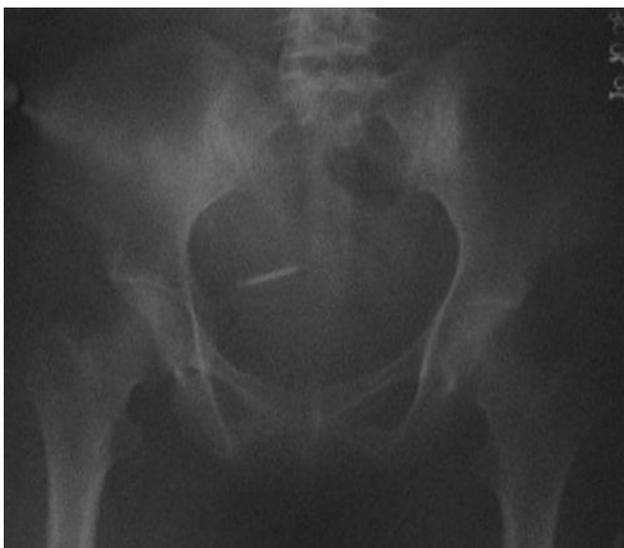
Misplaced Cu-T seen in pelvis on plain radiographs brought by patient
